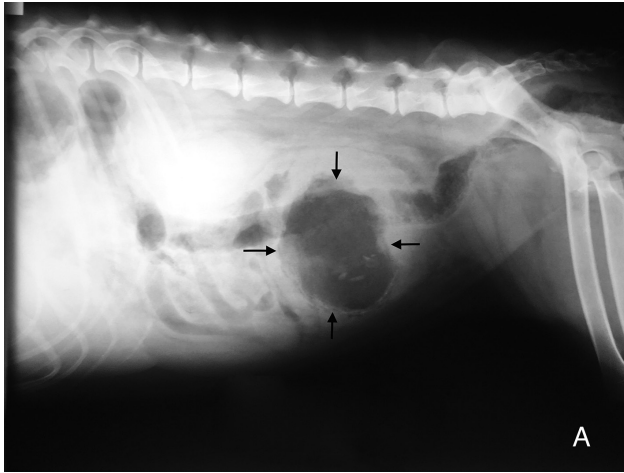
Same radiographic images as in Figure 1. In the mid to caudal portion of the abdomen, a cavitated mass with a gas-filled center and that also contains multifocal mineralized opacities (arrows) is evident.
